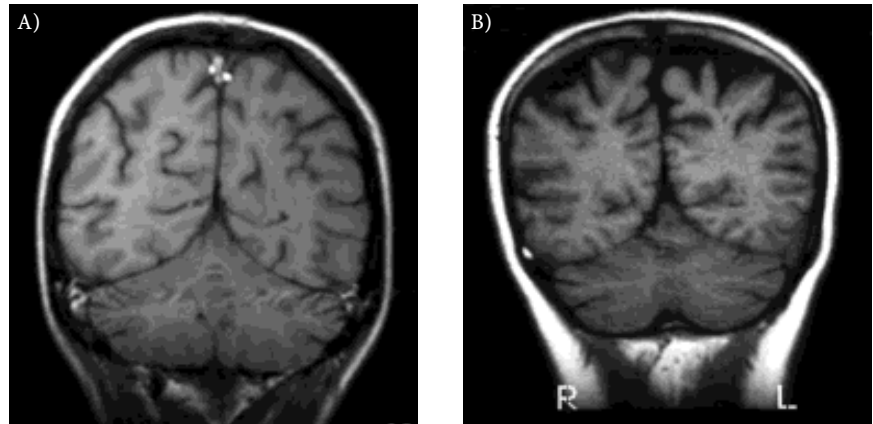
C Several small subcortical lesions (SSCL) – smaller than 1 cm – on T2-weighted and FLAIR MRI of the brain of a 48-year-old woman with 15 years duration of SLE and presence of lupus anticoagulant.
